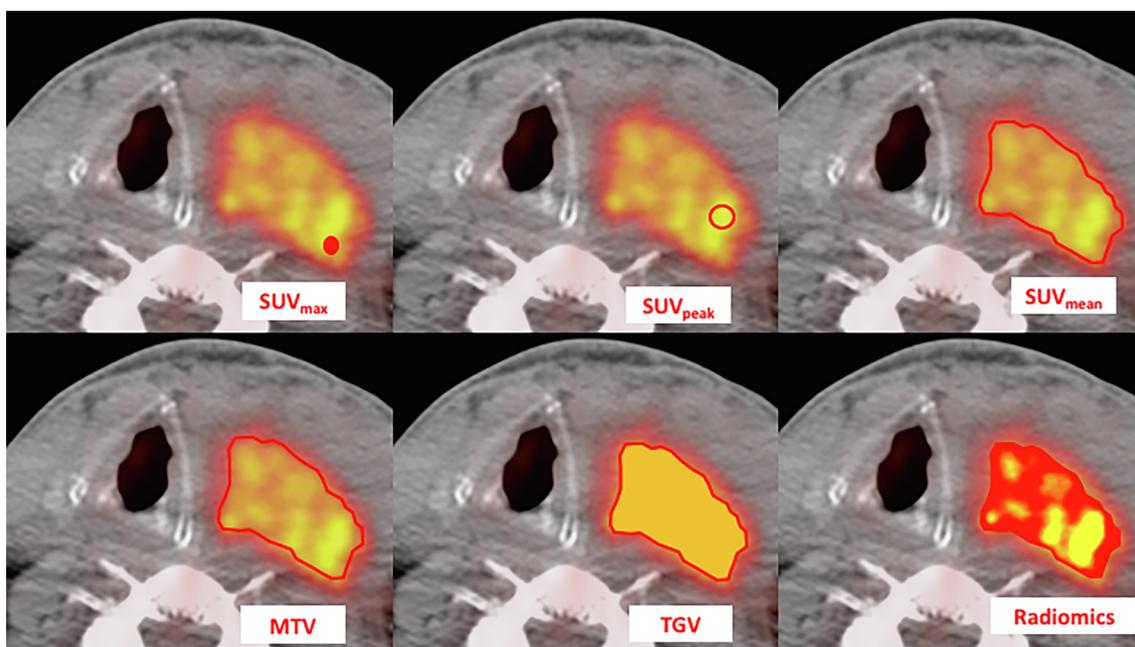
Different SUV metrics used for the definition of a large latero-cervical lesion: SUV_{max} is defined as the maximum value for SUV in the lesion, SUV_{peak} represents the maximum tumor activity within a 1 cm^3 volume in the hottest part of the tumor, SUV_{mean} is the average value of SUVs in a volume encircling the tumor, MTV determines the Metabolically active Tumor Volume, TGV is the Tumor Glycolytic Volume, that is the product of SUV_{mean} and MTV, and, the last Radiomics, indicating the ensemble of metrics describing the heterogeneity of the tumor.
